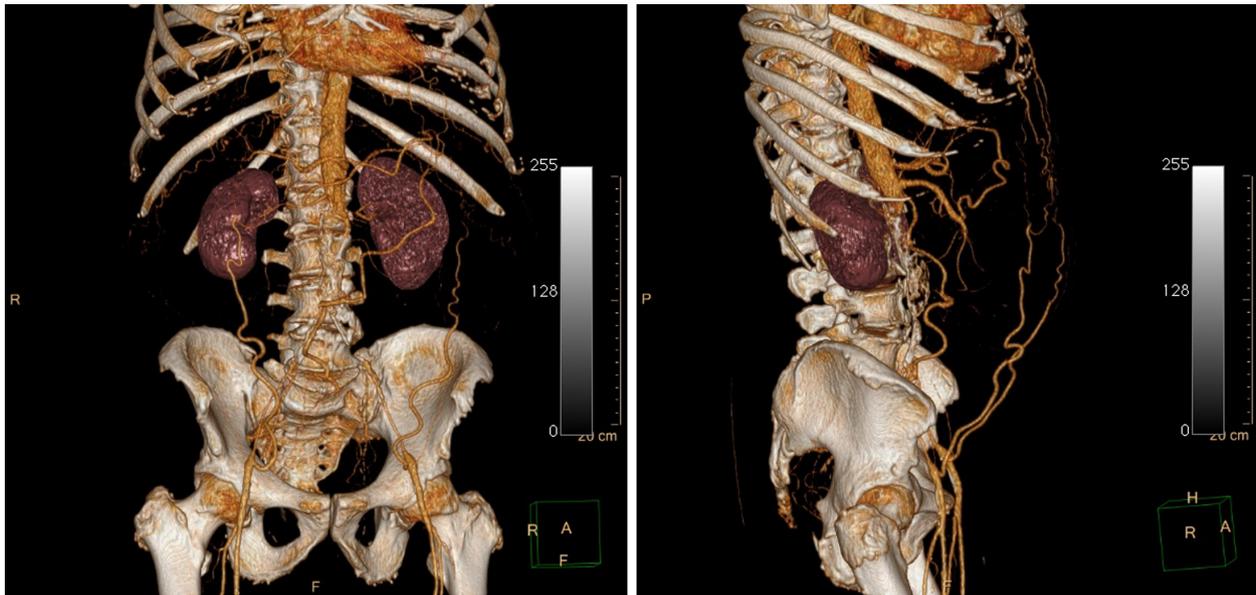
CT-scan of the abdominal aorta. The 3D-volume rendering image shows a complete obstruction of the subrenal aorta and iliac bifurcation. The vascularization of the internal and external iliac arteries and the common femoral arteries is maintained by collateral circles.
